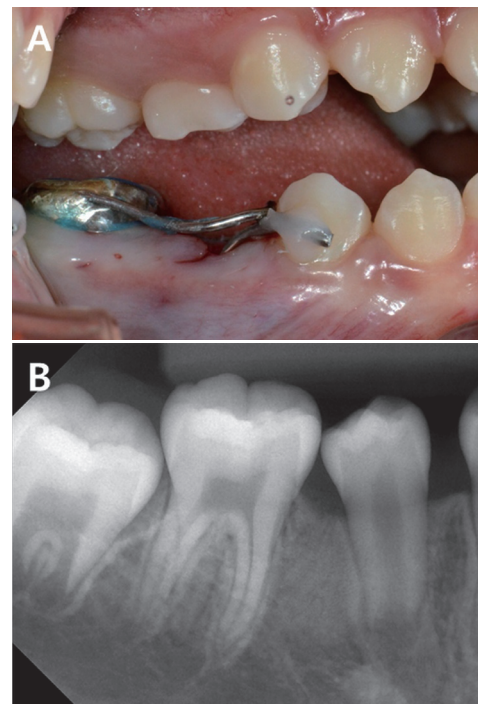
Intraoral view (A) after the marsupialization procedure shows a space-maintainer and a metal drain applied at the marsupialization cavity. It also can be seen that the primary molar involved was removed. Then, 6 months later, the periapical view (B) shows that the affected premolar erupted spontaneously.
